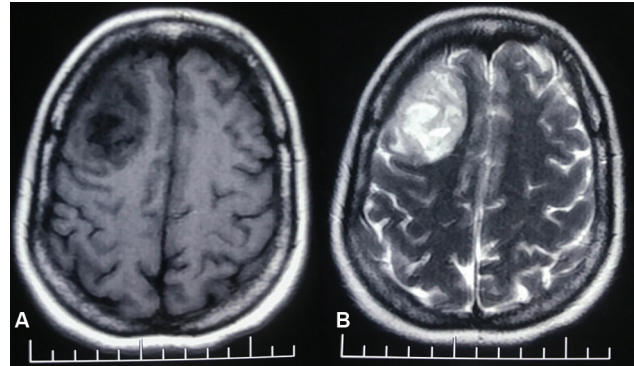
(A) T1-weighted magnetic resonance imaging (MRI) brain showing heterogeneously hypointense lesion in right frontal lobe. (B) T2-weighted MRI brain showing heterogeneously hyperintense lesion in right frontal lobe.
